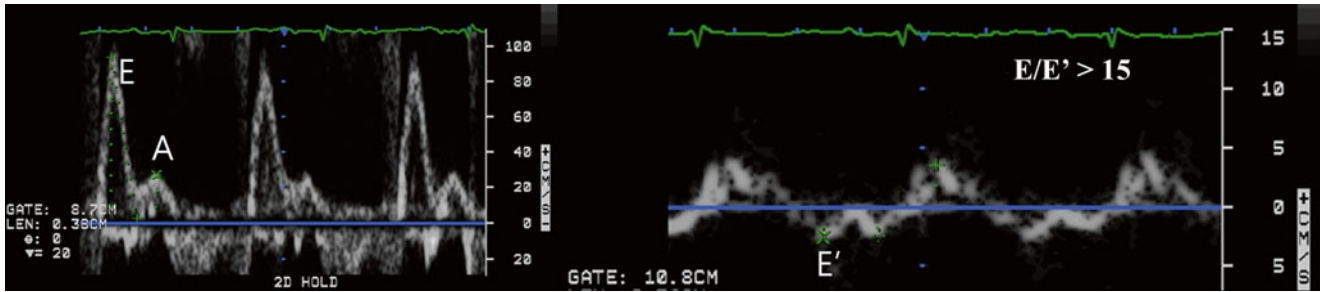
Typical Doppler pattern in restrictive physiology. Restrictive physiology is characterized by mitral flow velocities that show increased E velocity, decreased A velocity ($\ll E$), and shortened DT (<160 ms) and IVRT (<70 ms). Typically, the E/A ratio is more than
